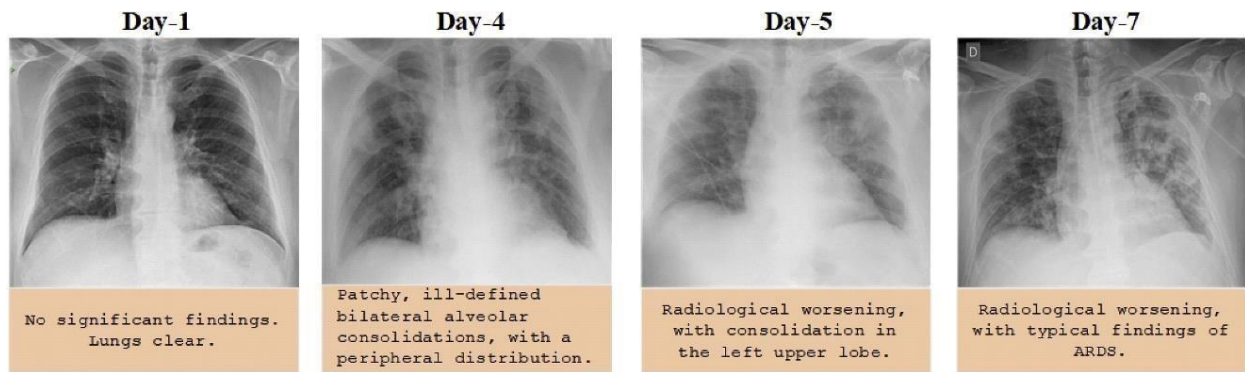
Chest X-ray images of a 50-year-old COVID-19 patient with pneumonia over a
